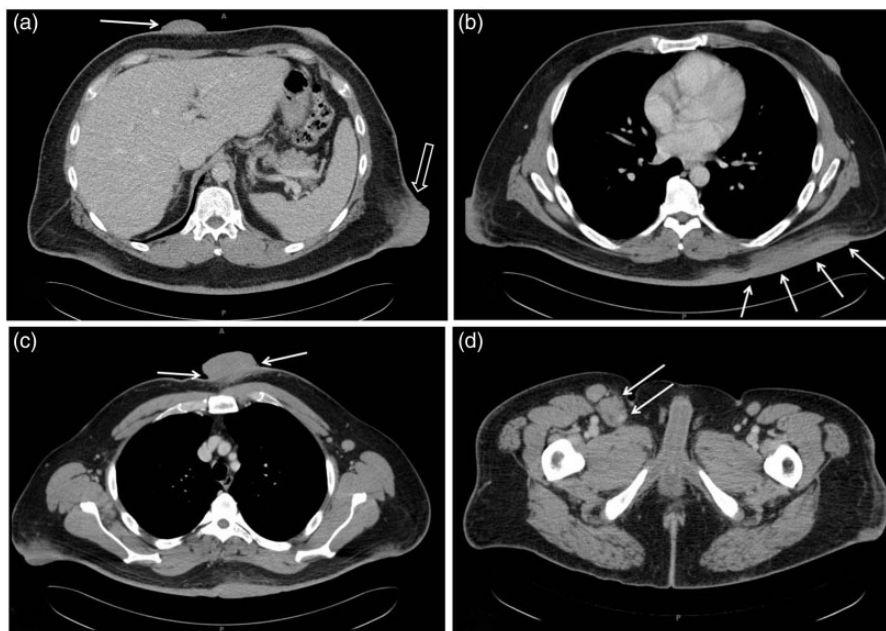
Axial contrast-enhanced CT images at different levels in the body. (a) A well encapsulated cutaneous mass in the anterior chest wall (arrow) with no underlying inflammation. A left lateral chest wall mass demonstrates underlying inflammation (open arrow). Underlying fat stranding extends to the level of the thoracic wall which is compatible with inflammation. No definite invasion of thoracic wall musculature is appreciated. (b) Plaque-like thickening of the left posterior thoracic wall (arrows). An intact fat plane separates the plaque-like thickening from the posterior thoracic wall. (c) Exophytic mass in the anterior chest wall with cutaneous and subcutaneous components. Mild subcutaneous inflammation is also noted without invasion of underlying musculature. (d) Enlarged right inguinal lymph node (arrows). A mildly enlarged left inguinal lymph node is also appreciated.
